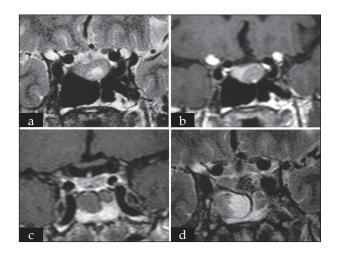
Preoperative (a and b) and postoperative (c and d) MRI of the patient
